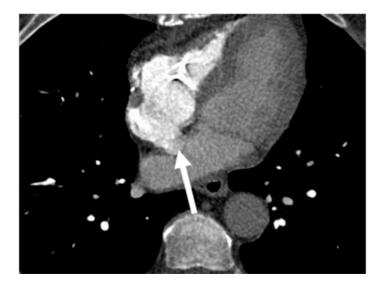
84 female admitted following collapse with mild SOB and raised D dimmers. Selected axial and short axis CT reconstructions show grossly hypertrophied left ventricle in the mid and distal walls & apex with mid cavity obliteration suggestive of HOCM. Figure 1c and 1d: Long and short axis MRI images show small left ventricular cavity and severe hypertrophy in the inferoseptal region and apical zones. The hypertrophied regions demonstrated poor contractility and and overall LV function was mildly impaired.
